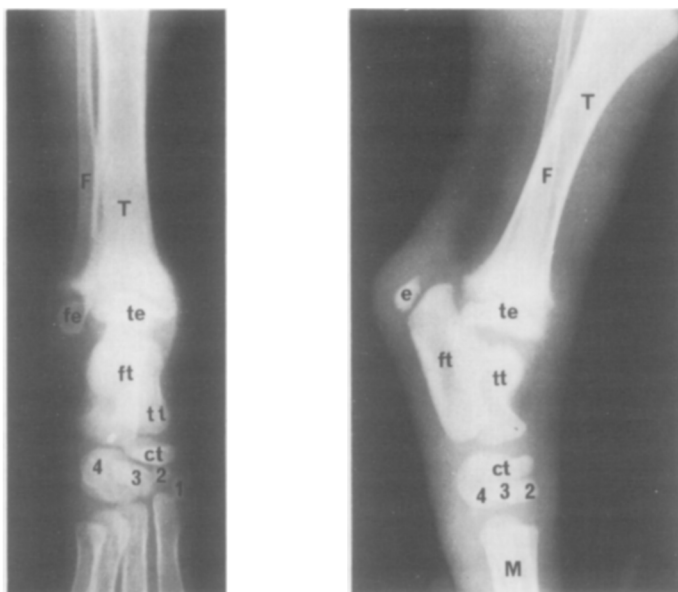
left. Dorso-plantar radiograph of the right tarsus of a 55-day-old Beagle. T=tibia, F=fibula, fe=fibular epiphysis, te=tibial epiphysis, ft=fibular tarsal, tt=tibial tarsal, ct=central tarsal, 1,2,3,4=tarsal bones.
